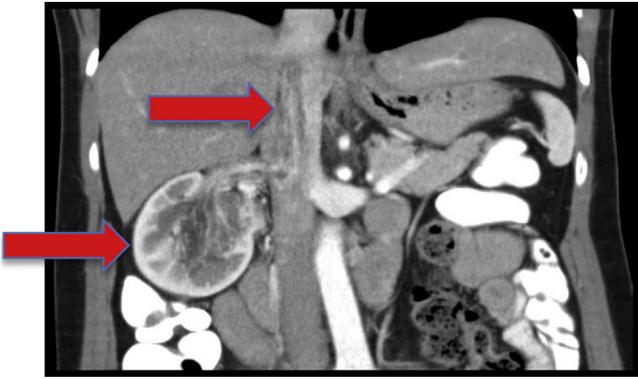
CT image of right renal tumour with caval thrombus.
